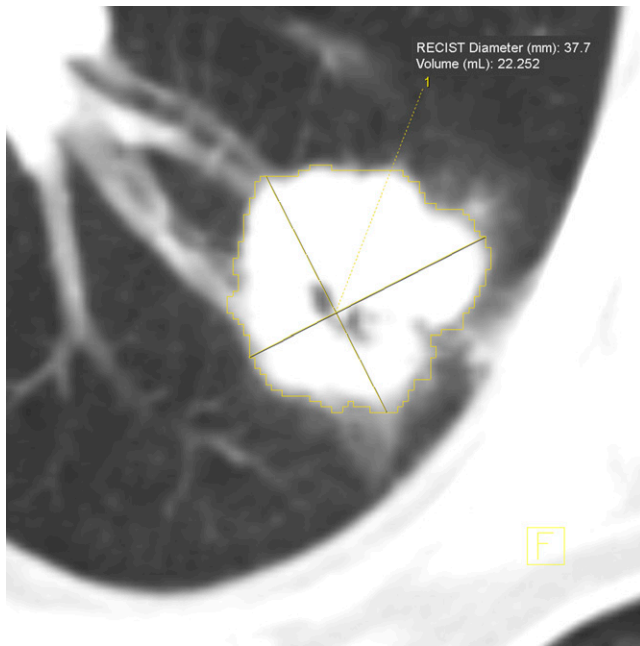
CT scan of patient with adenocarcinoma: yellow VOI encompasses total tumor volume. RECIST = response evaluation criteria in solid tumors.
